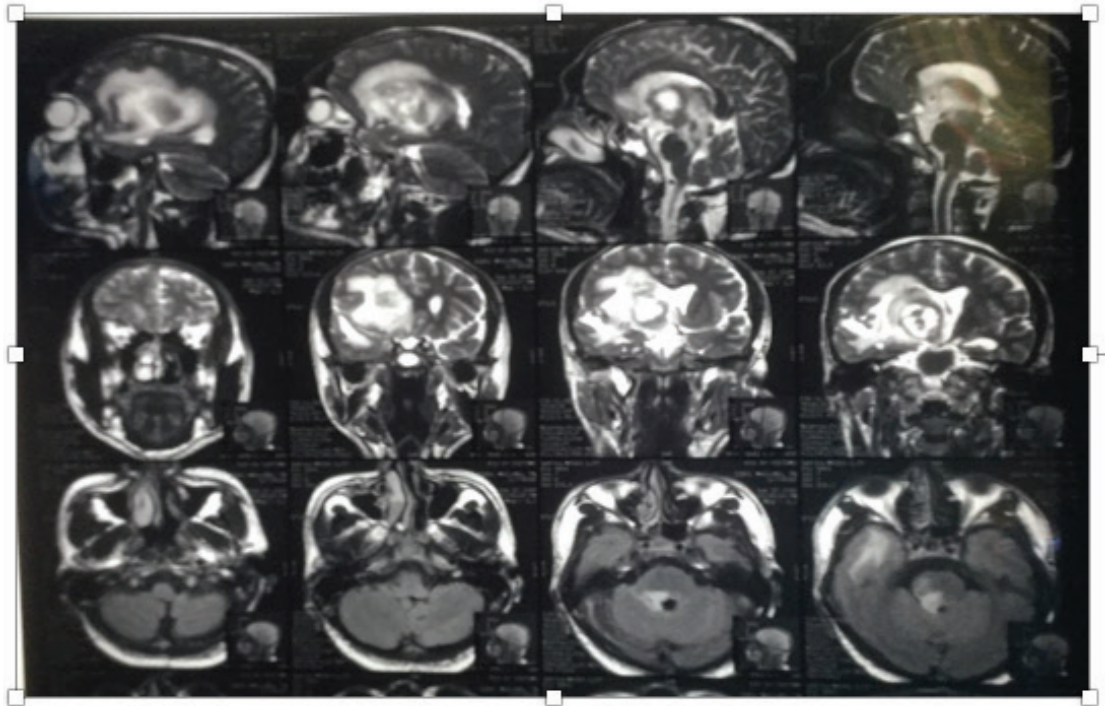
Patients head MRI with contrast showed a peripheral enhancing intra-axial, supratentorial lesion with hemorrhaging part and the necrotic area within the internal capsule suggesting a glioblastoma.
